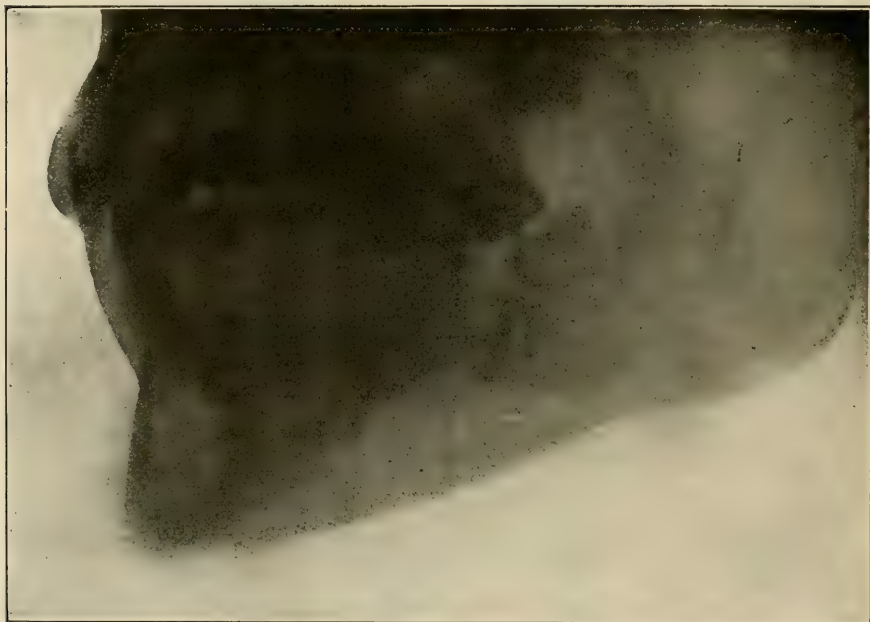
Lower third molar lodged between the first and second molars. (Radiograph by Pancoast, of Philadelphia.)
